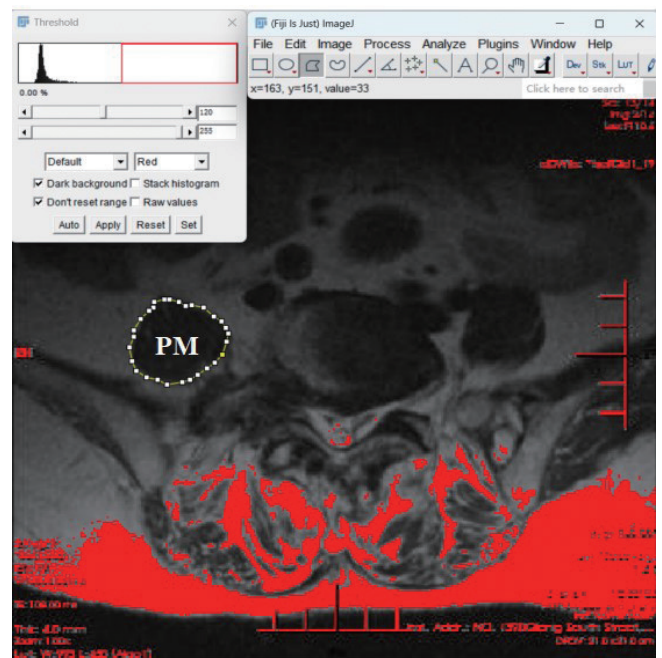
Measurement method of the PM FI. The Image J Threshold method on the middle layer of magnetic resonance image in each segment. Red pixels represent fat tissues. PM, psoas major; FI, fatty infiltration.
